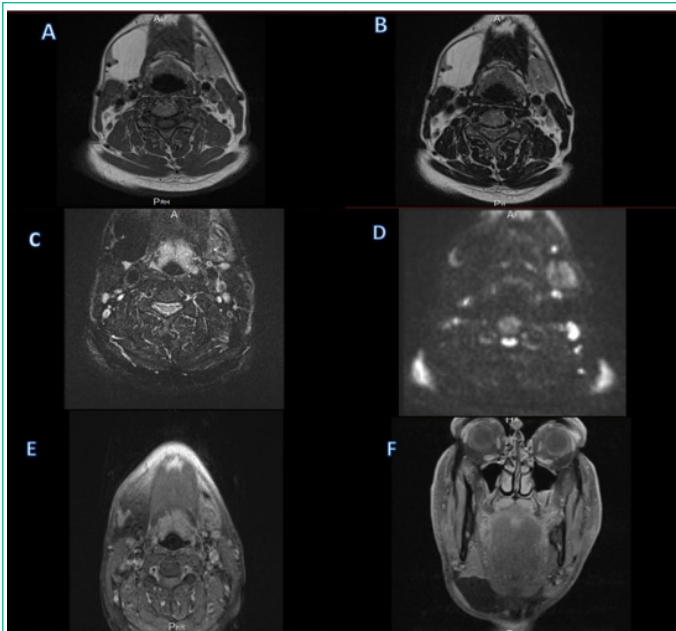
Cervicofacial MRI.
